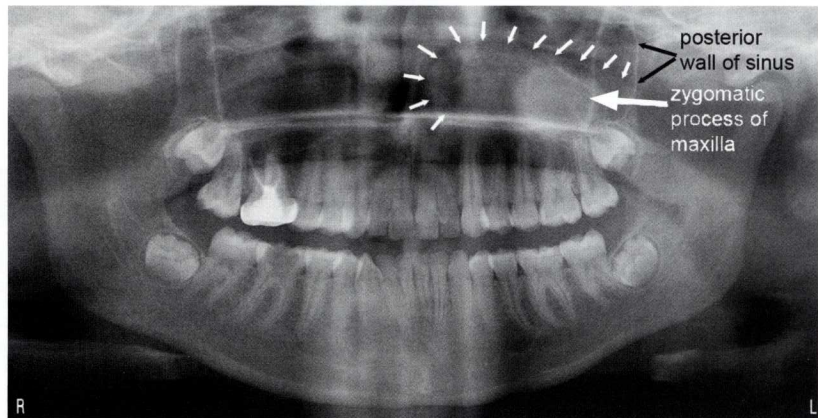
Panoramic radiograph showing the radiopaque inferior nasal turbinate (white arrows) superimposed on the left maxillary sinus. This superimposition is not as prominent in the right maxillary sinus as in the left sinus.
